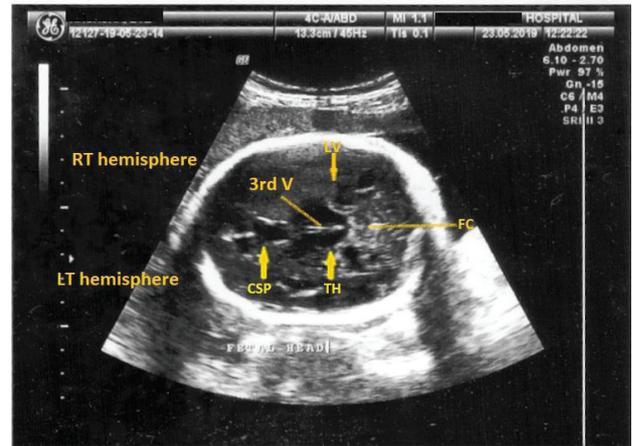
Transventricular ultrasound view used for measuring Head Circumference (HC) and Biparietal Diameter (BPD). Axial scan from the right occipito-anterior (ROA): a normal fetal calvaria housing the brain. Note the cavum of septum pellucidum (CSP), cerebral falx (CP), third ventricle, lateral ventricle (LV) and the thalamus (TH).
